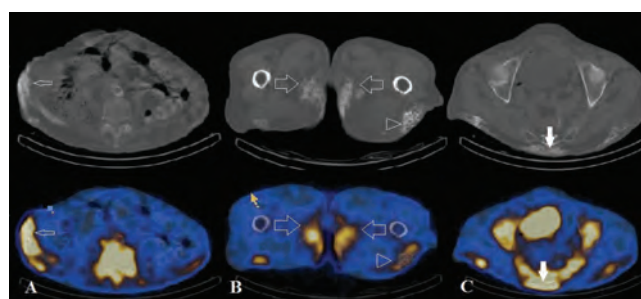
After the whole body scintigraphy, Single emission photon computed tomography was performed to the region of abdomen and pelvis. Axial Computed Tomography and fusion images showed the subcutaneous soft tissue calcification areas associated with nonhomogeneous increased osteoblastic activity in the lower abdominal wall (thin arrows) (A), bilateral proximal thighs (thick arrows), bilateral gluteal regions (triangular) (B), and around the coccygeus (white arrows) (C).
